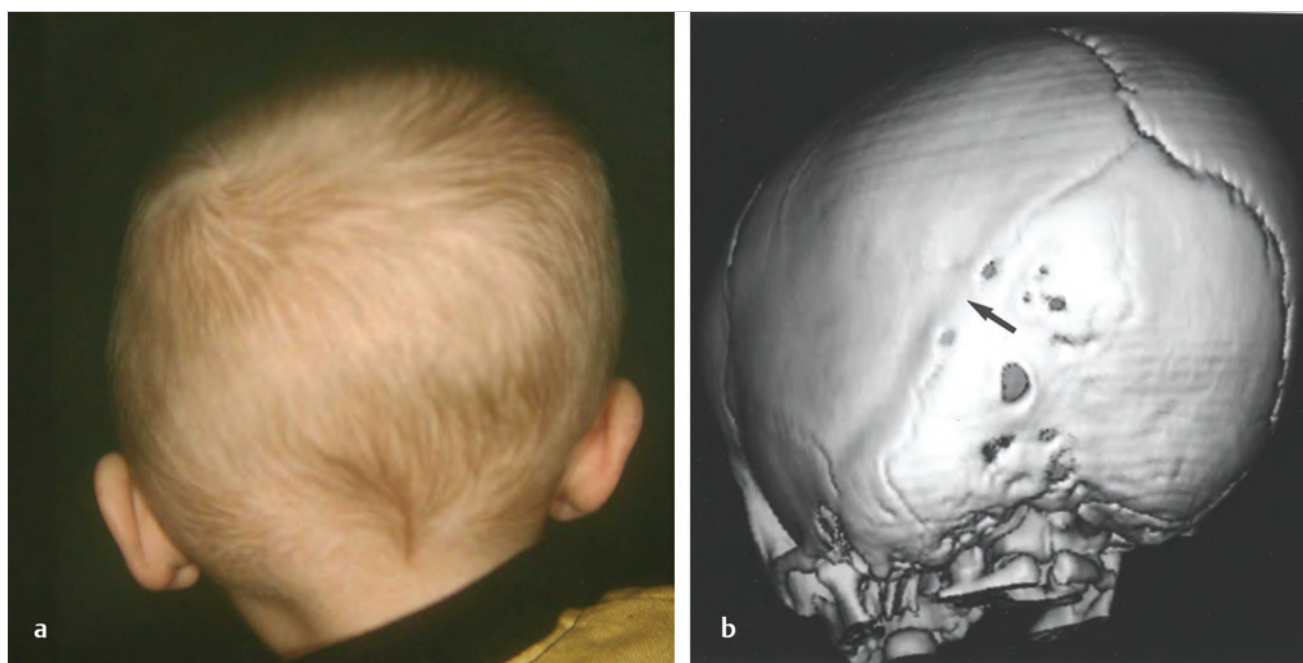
Left lambdoid synostosis. (a) Clinical appearance. (b) CT image demonstrating fusion of left lambdoid suture.
